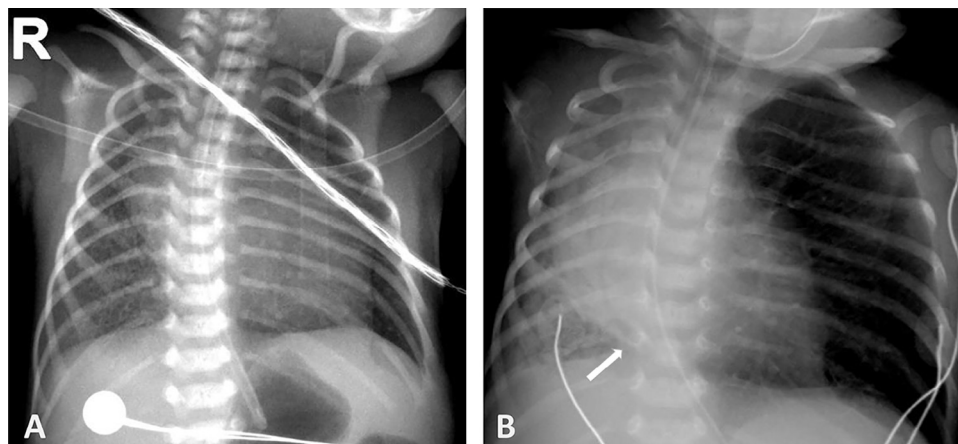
Preoperative (A) and postoperative (B) chest radiographs. The preoperative image shows mild interstitial thickening with normal lung aeration and the postoperative image shows opacification of the right lung with a dilated airway directed abnormally to the lower esophagus (arrow).
